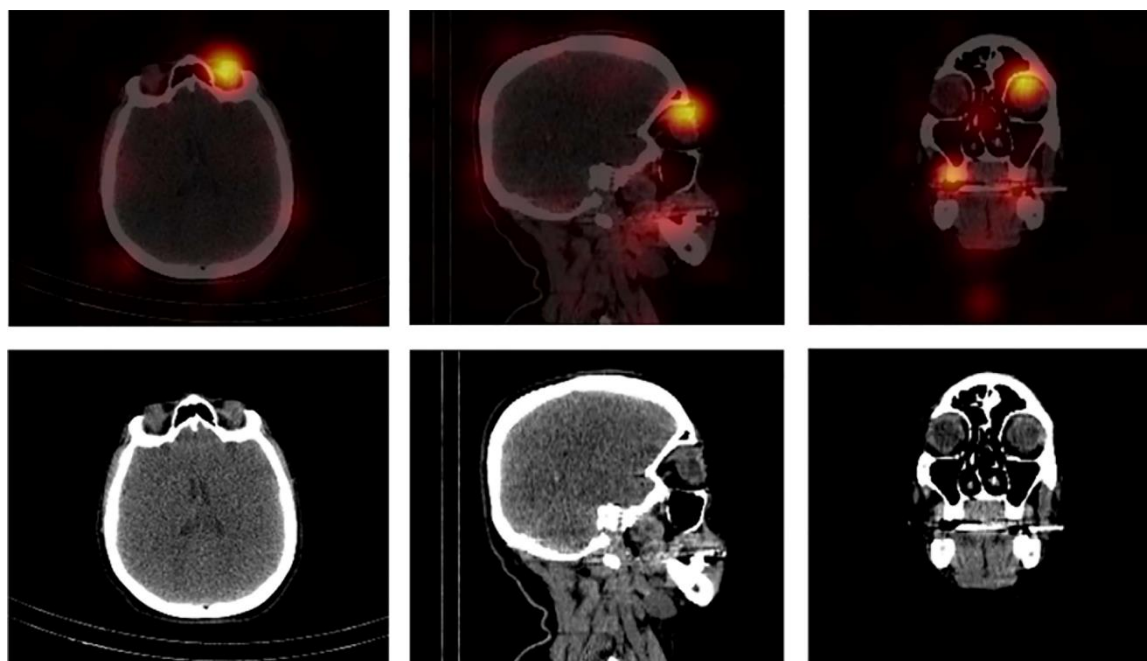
SPECT/CT scan for better localization and characterization of the uptake focus was done. Transaxial, sagittal and coronal slices of I-131 SPECT/CT fusion images (upper row) and corresponding CT scan slices (lower row) at the level of the orbits were shown. On a SPECT/CT scan, the I-131 uptake was localized in the left orbit
